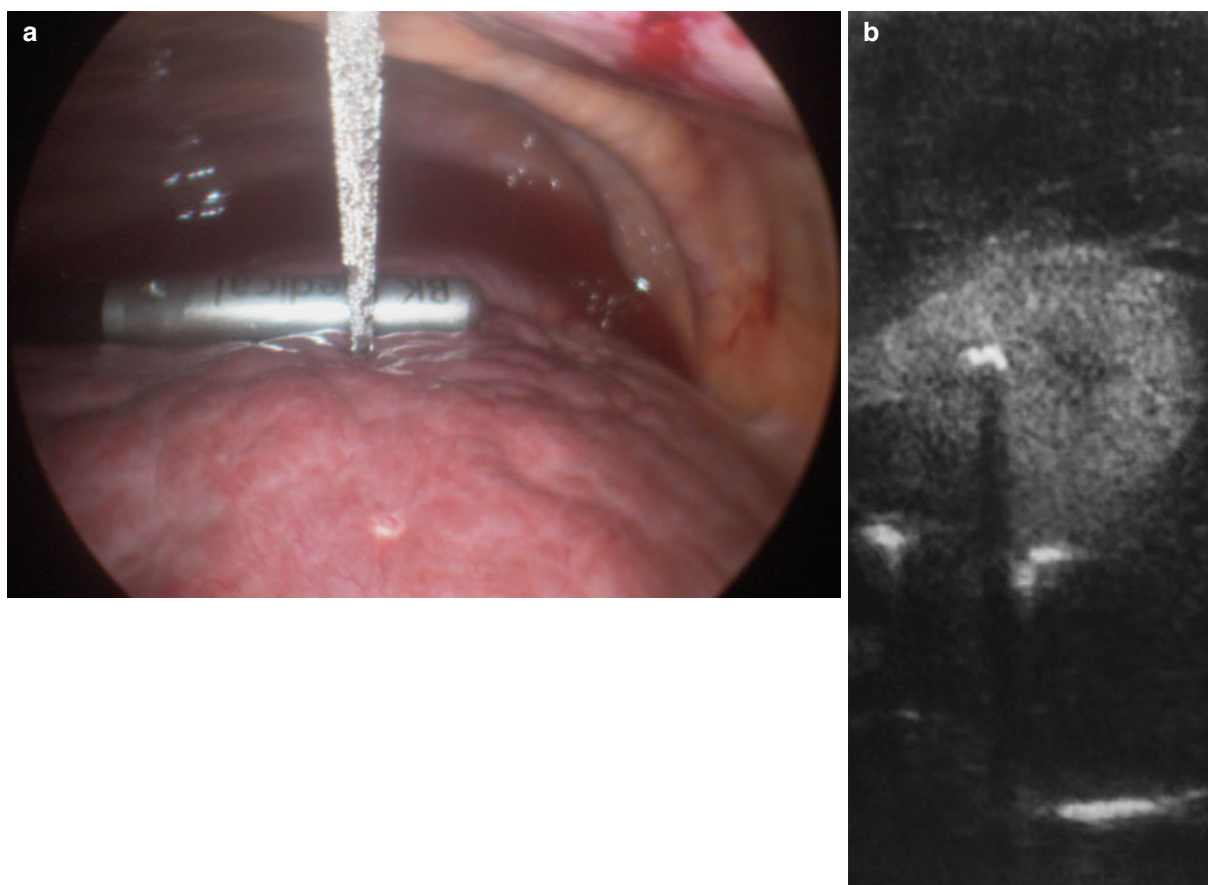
(a) A microwave antenna is advanced out of plane with the lesion. The lesion and antenna are visualized on-screen together only in the single instance of the antenna crossing the plane of the ultrasound
